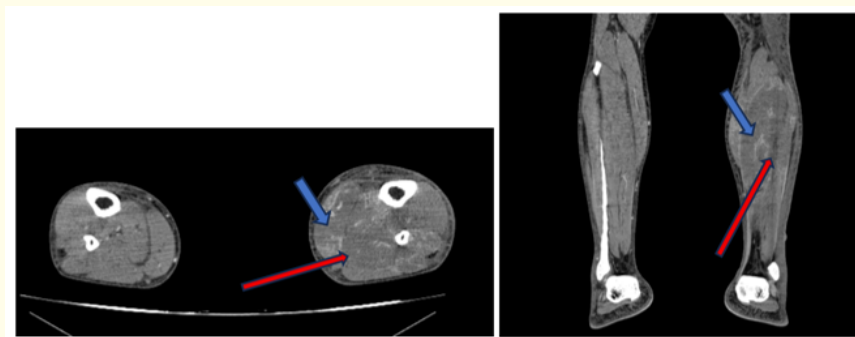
Contrast-enhanced CT of the lower limbs. Axial (A) and coronal (B) images show extensive non-enhancing defects involving multiple muscle compartments of the left lower limb (red arrow), with peripheral curvilinear enhancement (blue arrow) outlining the necrotic muscle, consistent with ischemic myonecrosis.
